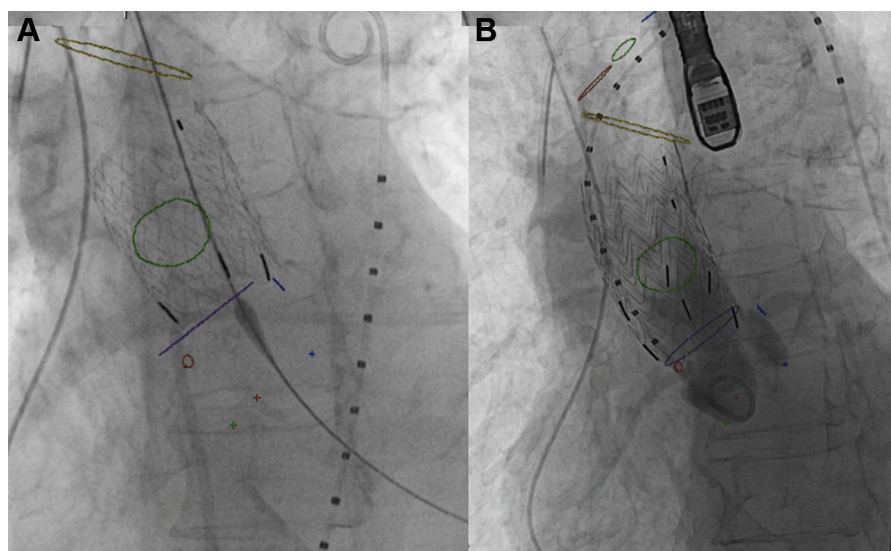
Aortic stent graft deployment. Live fluoroscopic image showing deployment of first (A) and second (B) aortic stent graft (cuff) in the ascending aorta using computed tomography (CT) image fusion markers. Image fusion markers: blue circle = left coronary artery ostium; blue dot = nadir of left coronary sinus; green circle = ostium of ascending aortic pseudoaneurysm; green dot = nadir of noncoronary sinus; purple circle (shown as a line) = sinotubular junction (STJ); red circle = right coronary artery (RCA) ostium; red dot = nadir of right coronary sinus; yellow circle = proximal origin of right brachiocephalic artery (BCA). Supra-aortic vessels: red circle = right BCA; green circle = left common carotid artery; blue circle = left subclavian artery.
